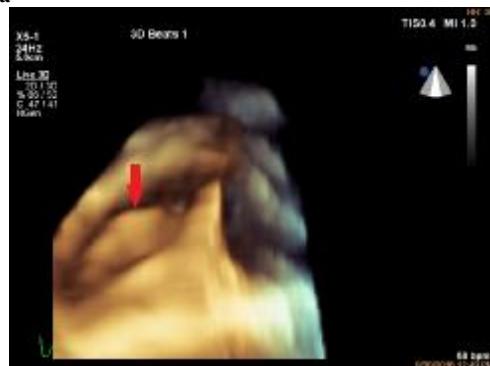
b) 3D ultrasound, transversal scan that shows the same thrombus in its distal portion
